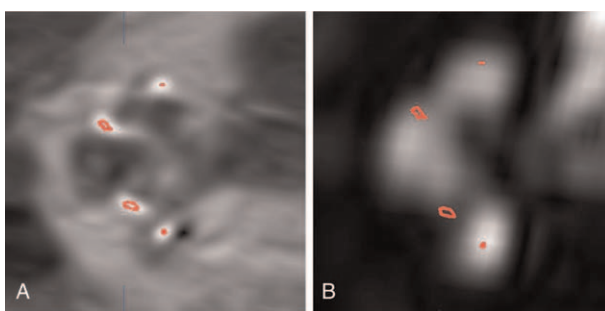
Deep insertion (insertion depth angles [IDA]=610 angles) with Flex28. The identification of the cochlear structures, especially after the basal turn, is deteriorated by the metallic artefacts on the postoperative CBCT (A). In the MRI image fusion reconstruction (B), the cochlear anatomy can be better depicted and hence the related electrode locations. CBCT indicates cone-beam computed tomography; MRI, magnetic resonance imaging.
